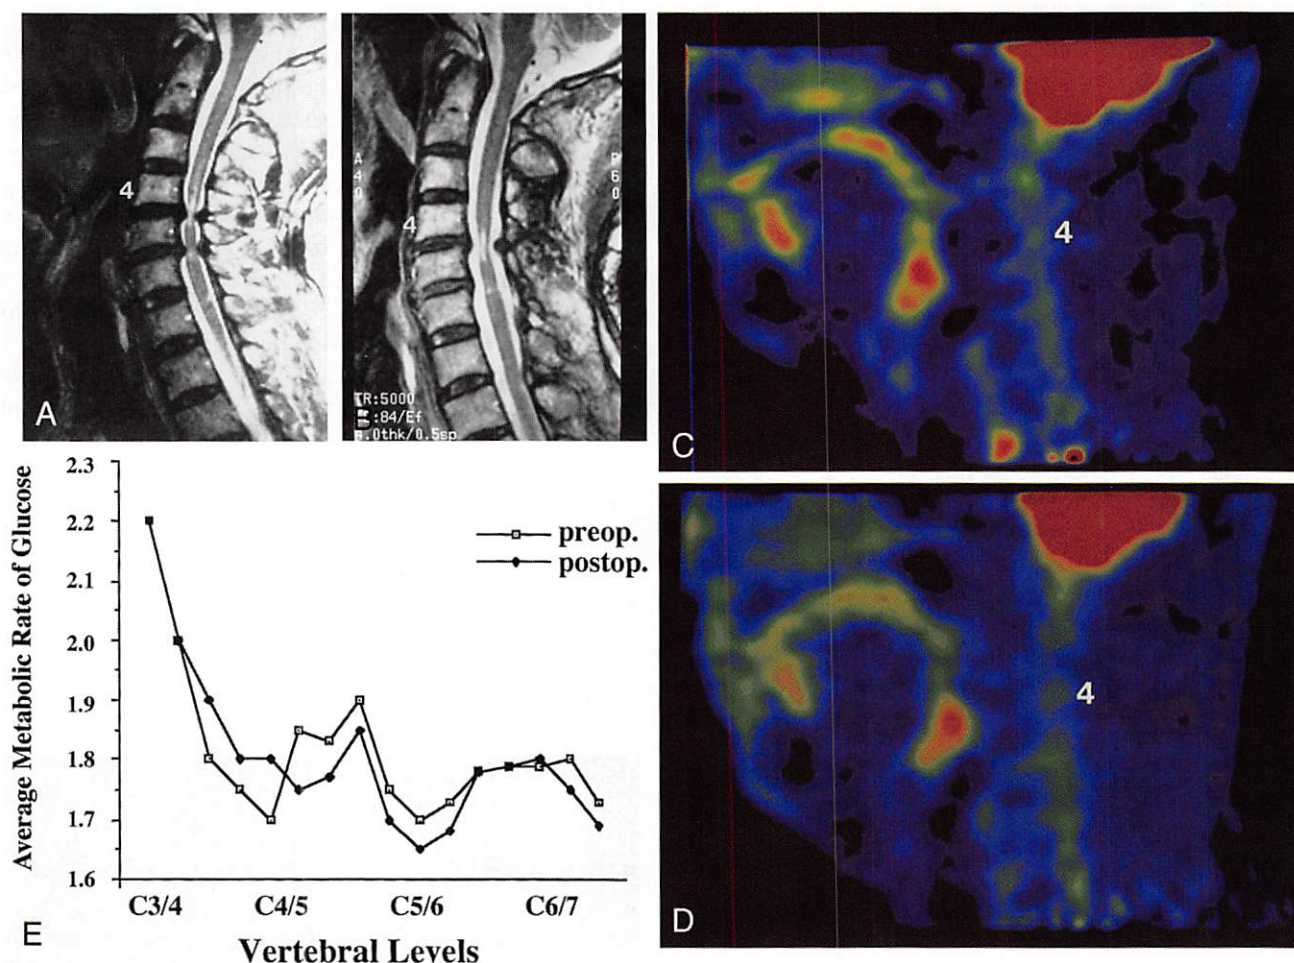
Preoperative (A) and postoperative (B) T2-weighted (TR, 5000 msec; TE, 84 msec) magnetic resonance images of case 6. Positron emission tomography images before (C) and after (D) C3-C7 laminoplasty^{3,5} are also shown. 4 = location of C4. There are no significant changes in the average metabolic rate of glucose (shown in milligrams per minute per 100 g brain) between different vertebral levels and between preoperative and postoperative images (E).
